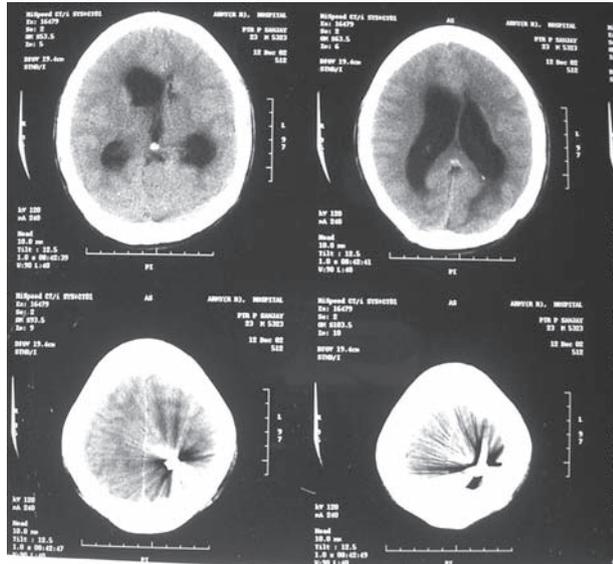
CT showing retained intracranial shrapnel and hydrocephalus
